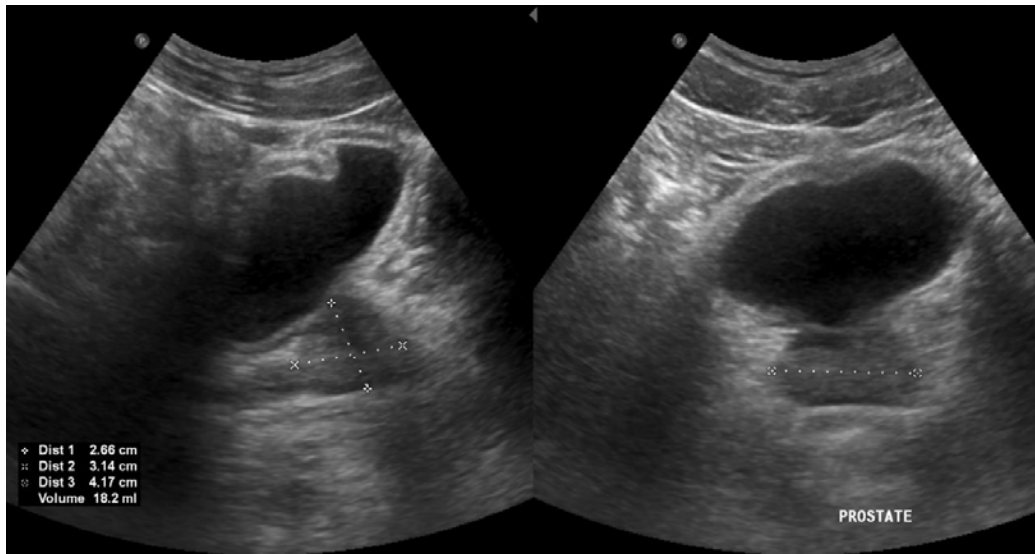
Example of ultrasound measurement of prostate volume on trans-abdominal ultrasound in a 40-year-old man. Source: Image obtained from patient records with permission.
